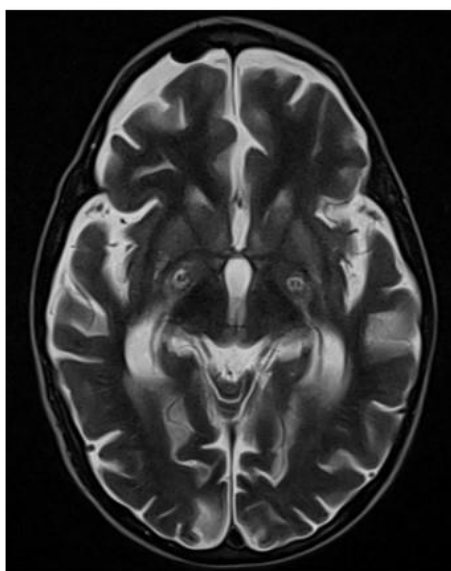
Postoperative MRI showing BP in a T2 weighted sequence
